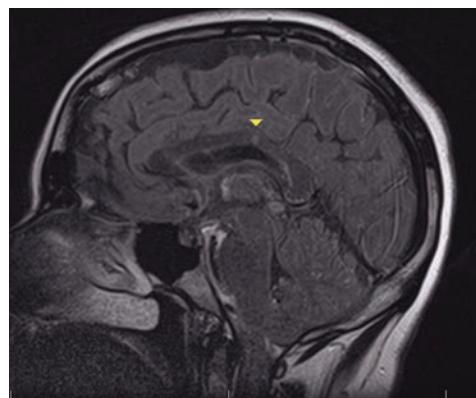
Fluid-attenuated inversion recovery MRI shows a focal hyperintense foci in the corpus callosum (arrowhead).
